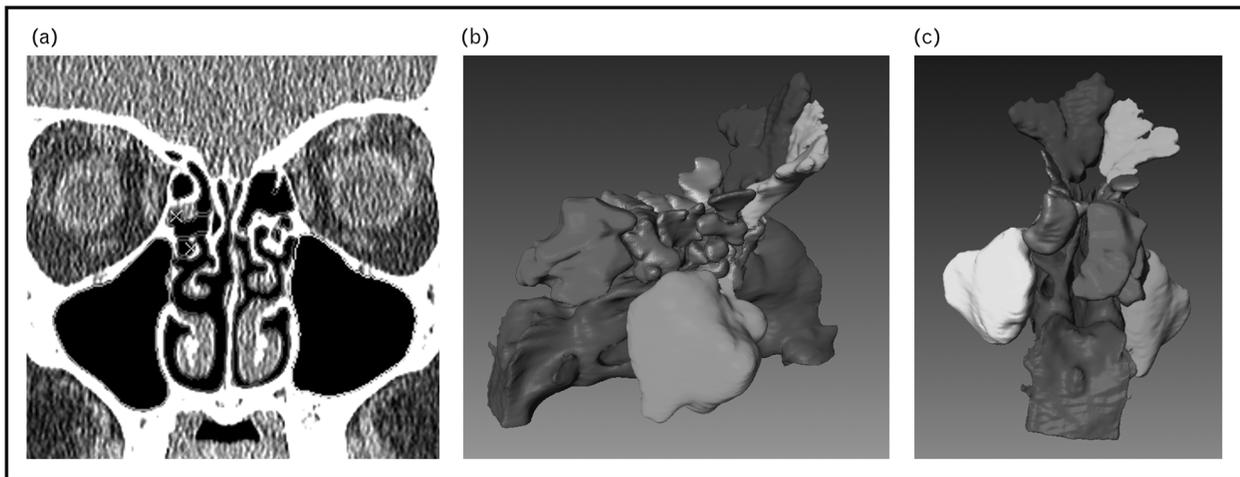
(a) Coronal slice from individual CT scan, showing nasal airway and nasal sinus outlines. CT scan slices were compiled to produce three-dimensional model (b, c).
